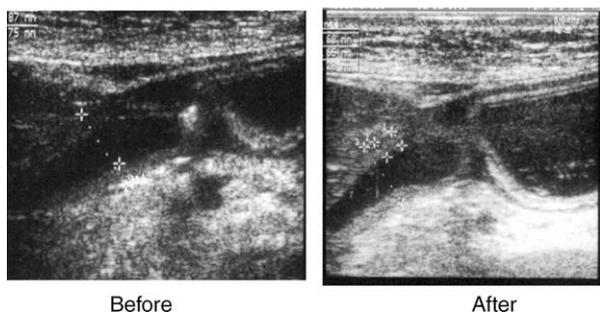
Ultrasonographic pictures of the distal gastric antrum, pylorus and duodenal bulb before and after provocation with an allergen through a nasojejunal tube in patients with food allergy. Note increased bulb diameter and wall thickness after provocation (the two pictures are zoomed differently). Transabdominal ultrasonography performed with a 5.0 MHz curvilinear transducer. From Arslan et al. (2005).
